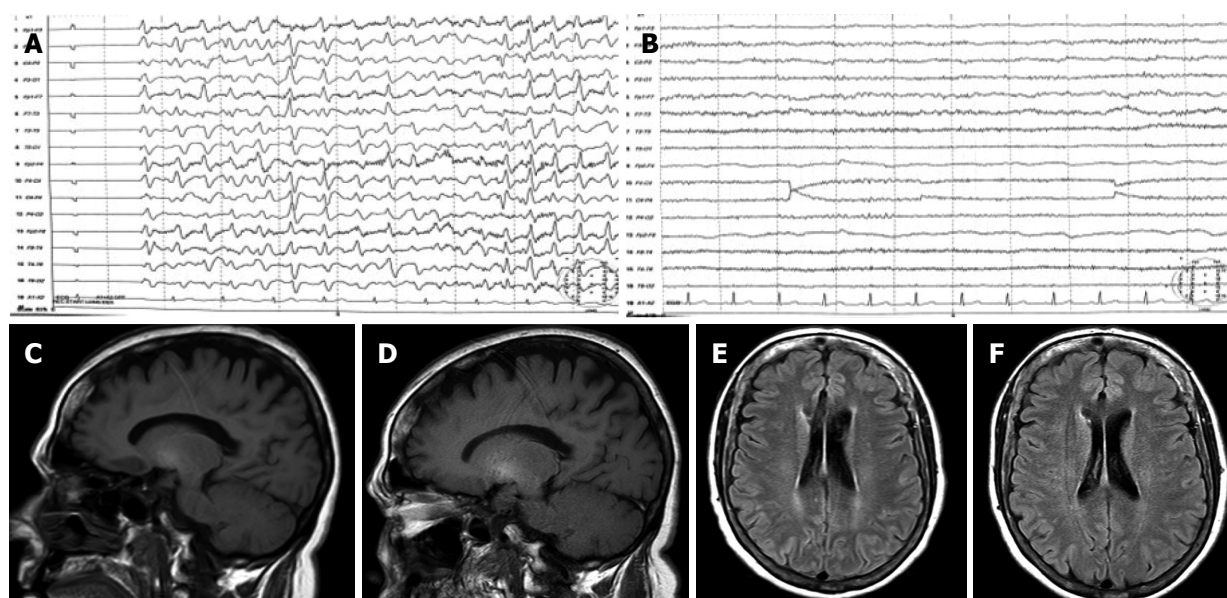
Electroencephalograph and magnetic resonance findings at baseline and after treatment with thyroid hormone. A: EEG at baseline showing slow activity and generalized triphasic waves; B: EEG after treatment showing normalization of brain activity; C: T1-weighted MRI showed high-signal in basal ganglia at baseline; D: T1-weighted MRI performed after thyroid hormone replacement showed non-significant changes; E: FLAIR MRI sequence at baseline demonstrated subtle periventricular white matter hyperintensities; F: FLAIR MRI image after thyroid hormone replacement demonstrated a normalization of periventricular white matter signal abnormalities. EEG: Electroencephalograph; MRI: Magnetic resonance imaging.
